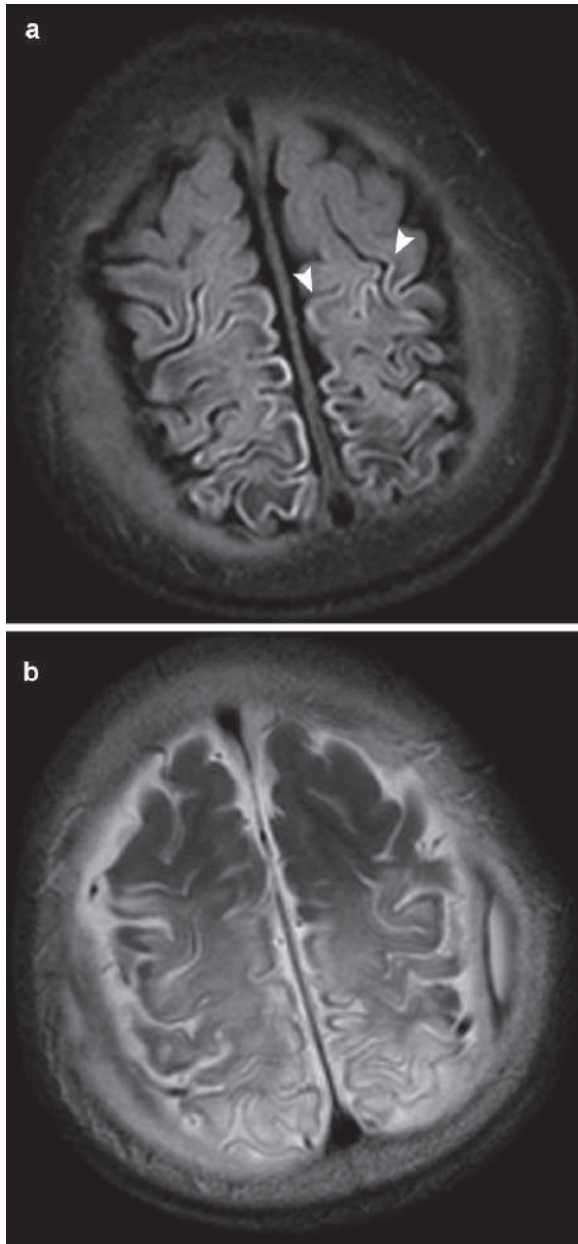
Axial T1W (a) and T2W (b) brain MRI in a 7-year-old child with chickenpox encephalitis shows cortical laminar necrosis (CLN). Notice the curvilinear hyperintense signal intensity lines that follow the convolutions of the gyri on both hemispheres (*arrowheads*), with diffuse white matter lesions seen on T2W images
